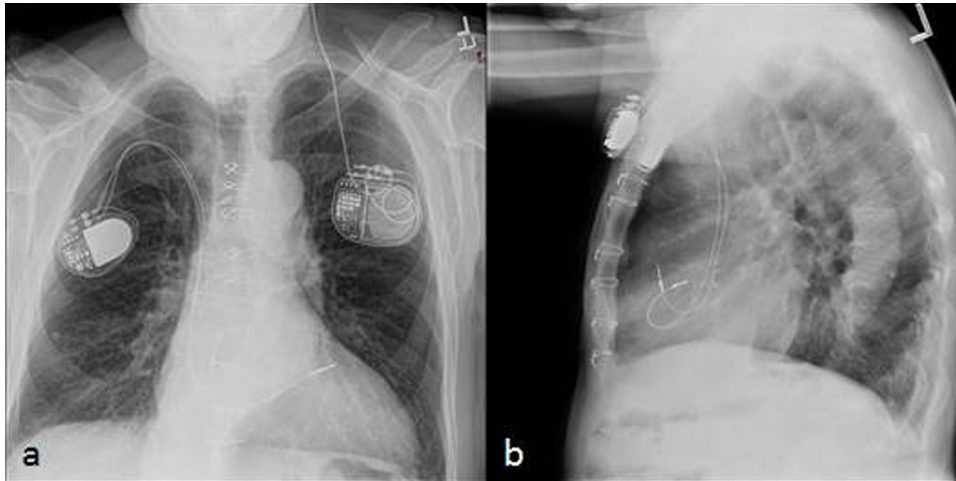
X-ray chest postero-anterior (1a) and lateral view (1b) shows the position of DBS pulse generator (left chest wall) and cardiac pacemaker (right chest wall). Note the distance between two devices >6 in.
